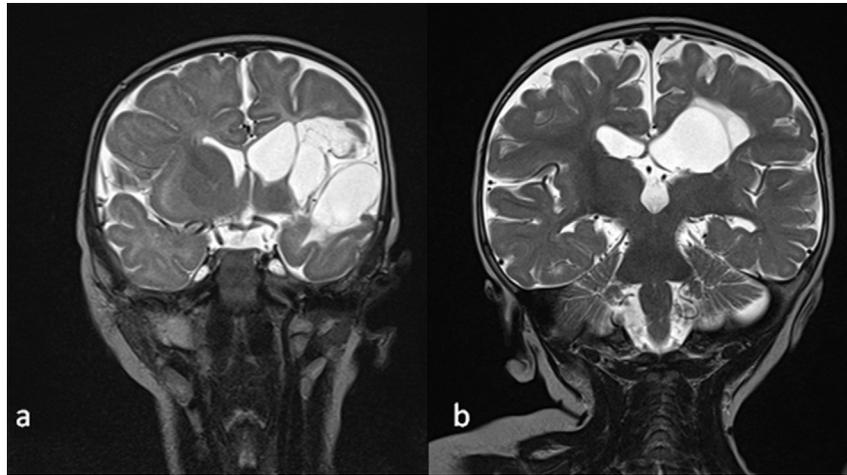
Coronal T2-weighted images of two children who presented with delayed onset. a) A large porencephalic cavity in the left sylvian territory is seen in this 5-month-old boy who was seen first in the emergency department with infantile spasms. Simultaneously, the parents were reported diminished reaching and grasping of the right hand. (b) This child was referred due to left hand preference at the age of 7 months. Left periventricular white matter loss is well visible.
